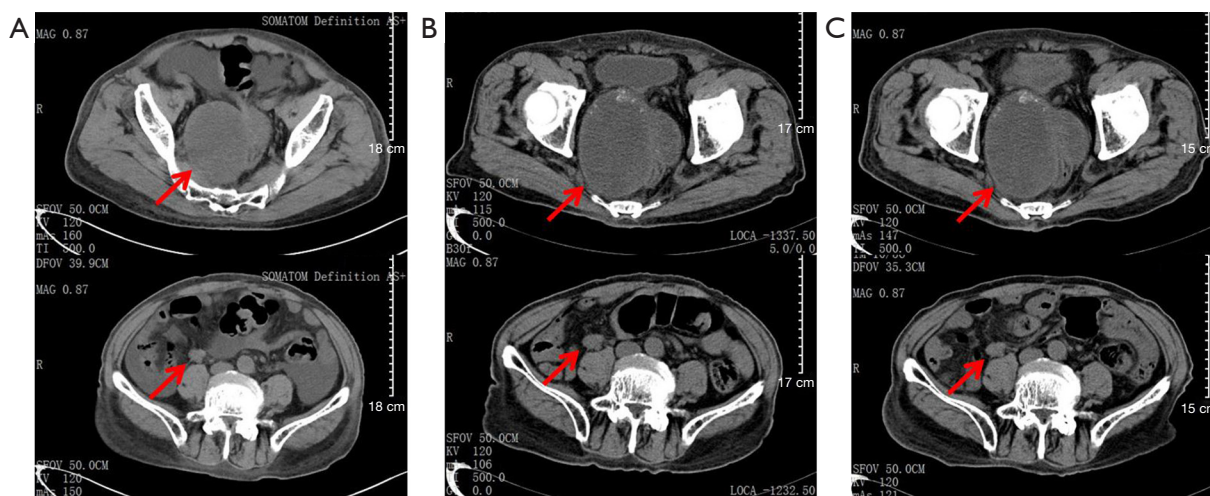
Abdomen CT images during follow-up at 2 months (A), 14 months (B), and 25 months (C) after fruquintinib treatment. The red arrows refer to a giant metastasis in the pelvic cavity and a mesenteric lymph node metastasis.
